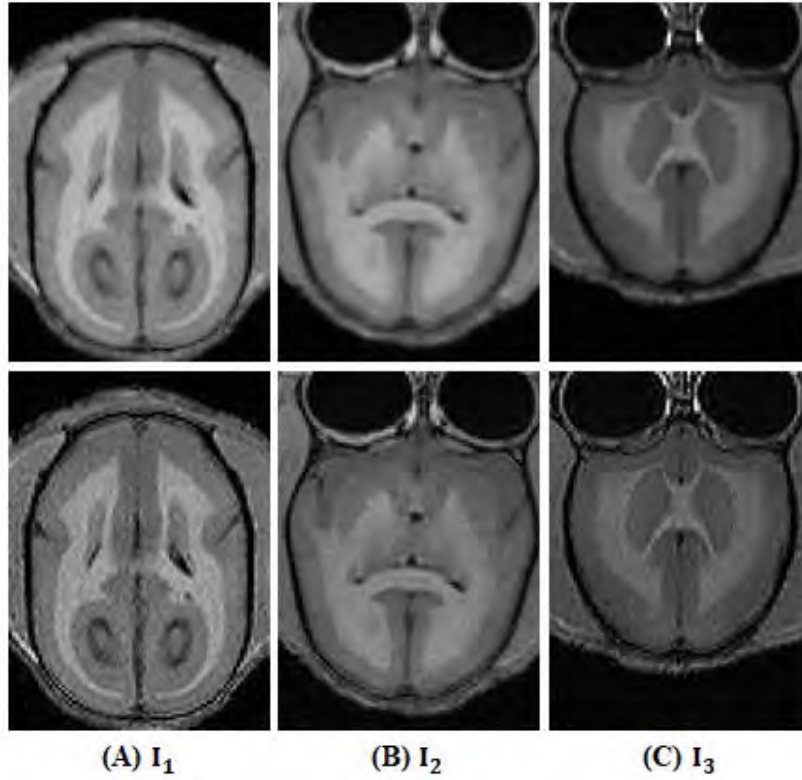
Results of image deconvolution by JMCMC algorithm for 3 axial slices ( $I_1$ ,  $I_2$  and  $I_3$ ) of the 3 MRI volumes. Top: the native images. Bottom: the enhanced (deconvolved) versions.
